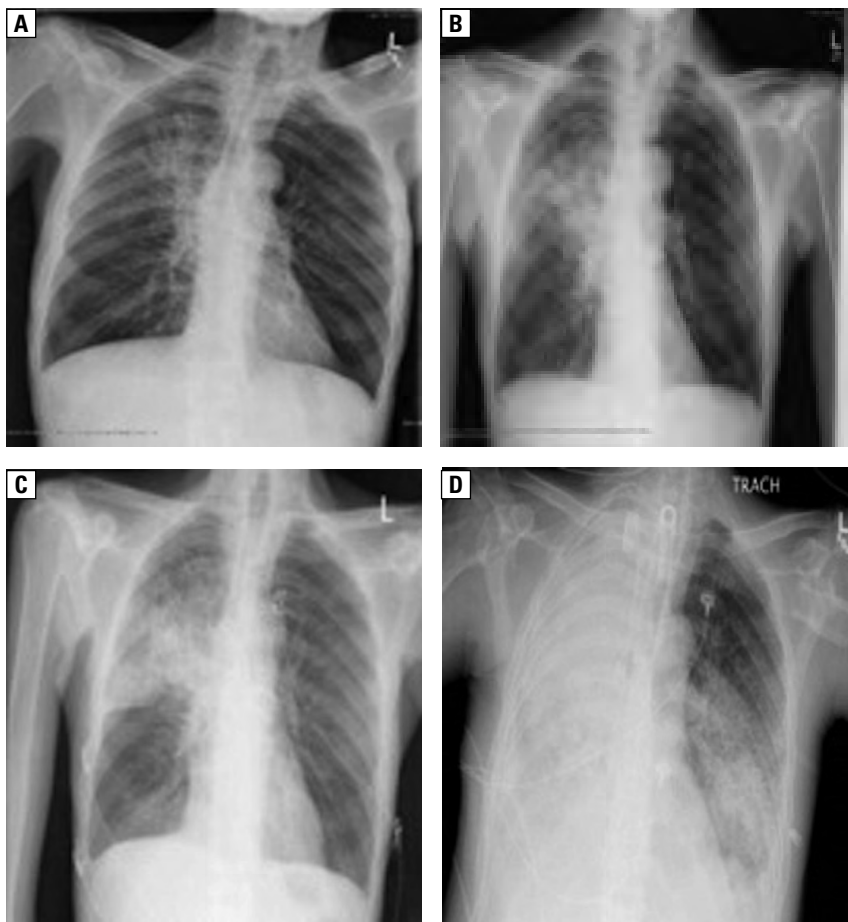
Chest X-ray results showing progression of RUL infiltrates to bilateral lungs from day 1 (A), 3 (B), 4 (C), and 8 (D) of admission respectively
